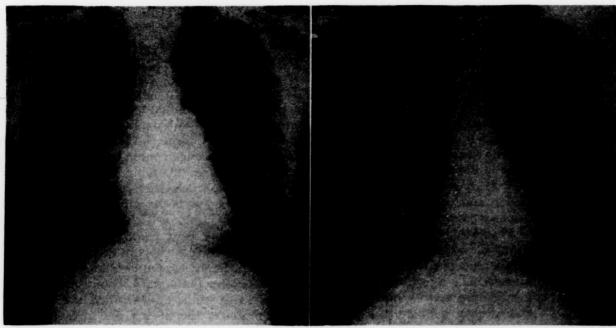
X-ray of the chest two and one-half months after initiation of cortisone therapy.
